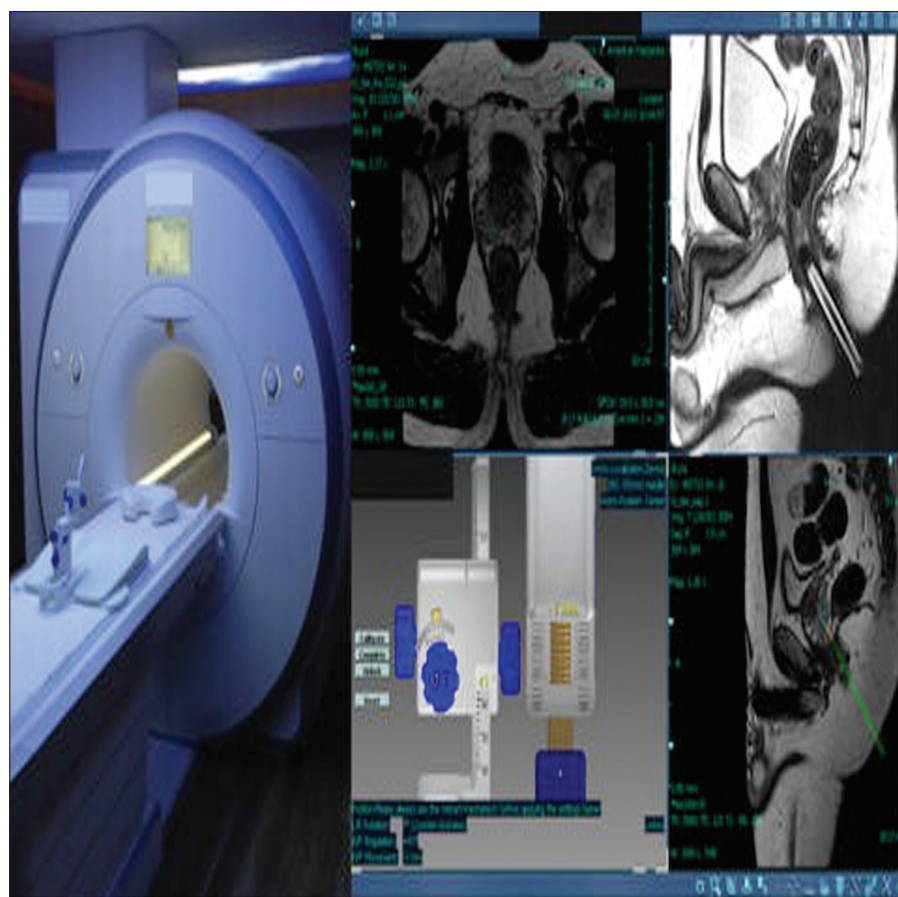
The hardware and software used during in-bore MRI-guided transrectal prostate biopsies.
